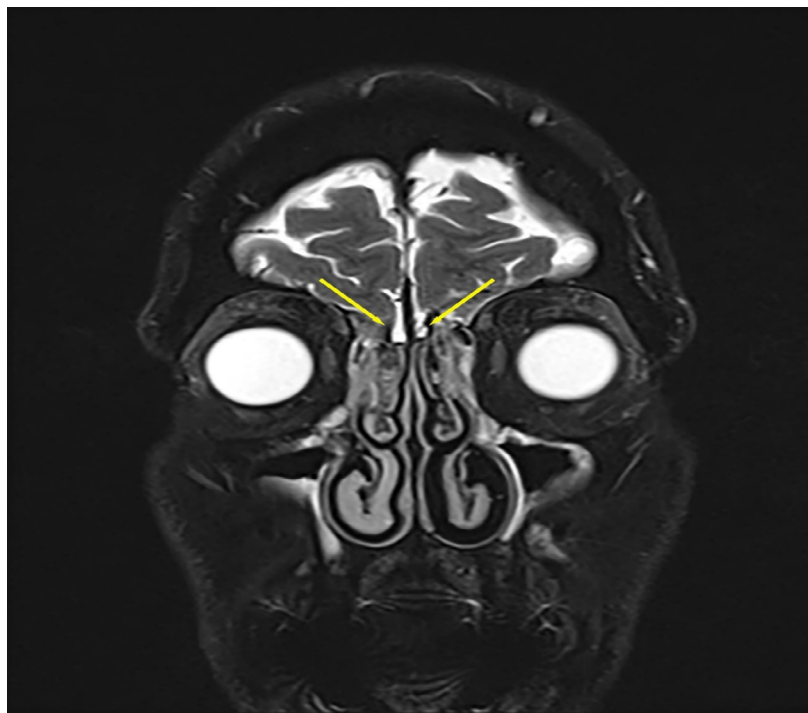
Patient MR image showing the absence (arrows) of the olfactory bulbs and the olfactory sulcus in the left frontobasal area.
